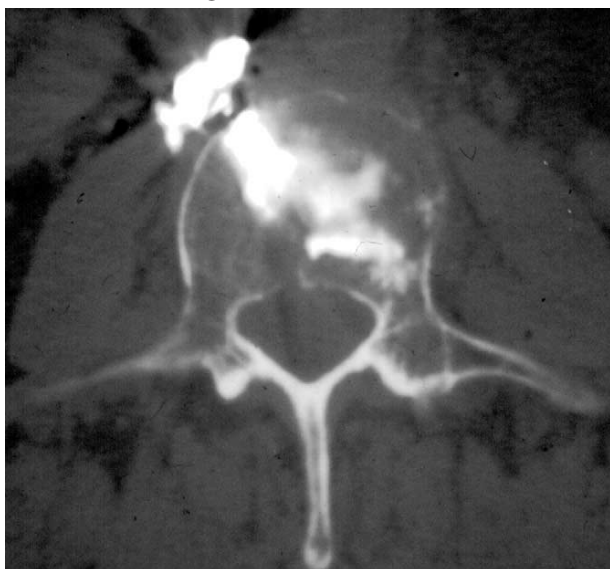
CT scan postvertebroplasty of a vertebral fracture of L3 due to metastatic disease: Cement extravasation in the prevertebral soft tissue.
